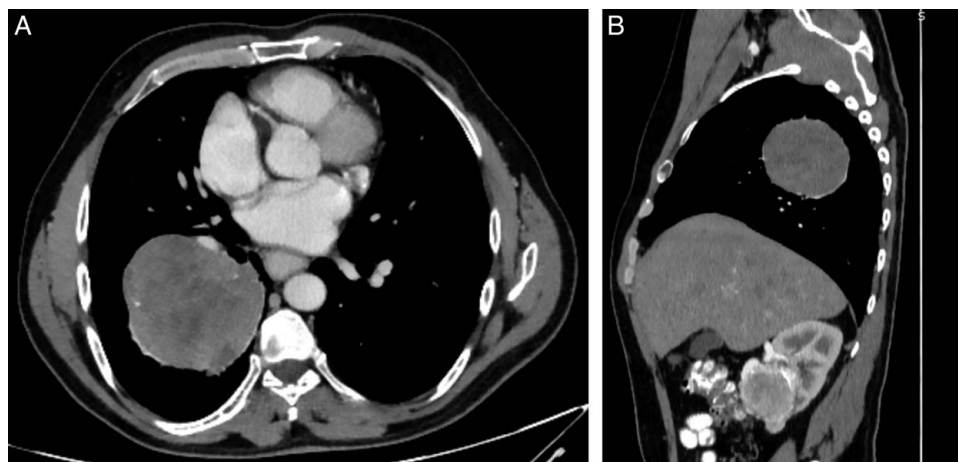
Axial and sagittal computed tomography (CT) images showing right middle lobe lung mass. Axial (A) and sagittal (B) CT images a large, well-defined soft tissue lesion in the right middle lung zone, partially encasing the interlobar pulmonary artery and the right intermediate bronchus, measuring $\sim 9.5 \times 8.5$ cm.
